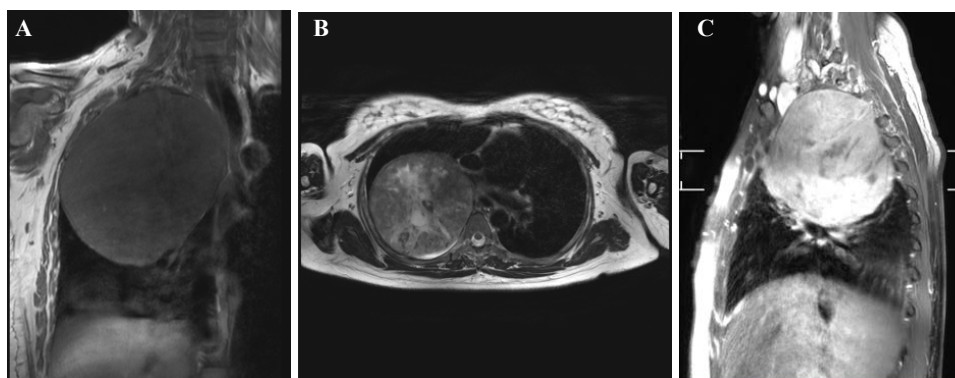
Magnetic resonance images of the thorax showing the heterogeneous-intensity mass in the right apical region, with areas of necrosis and compression of the surrounding structures. (A) T1- and (B) T2-weighted images; (C) postcontrast image
